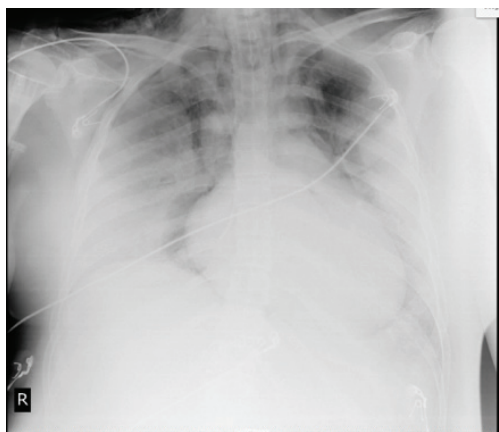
Chest x-ray before thoracic drain placement.
